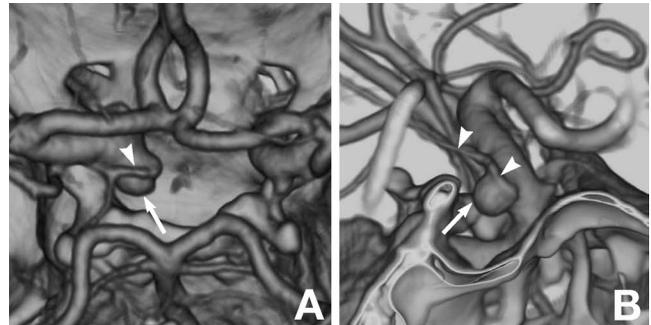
Axial (A) and lateral projection (B) three-dimensional computed tomography angiograms showing fenestration of the left supraclinoid internal carotid artery (arrowheads) with an associated aneurysm (arrow) at the proximal end of the fenestration.
